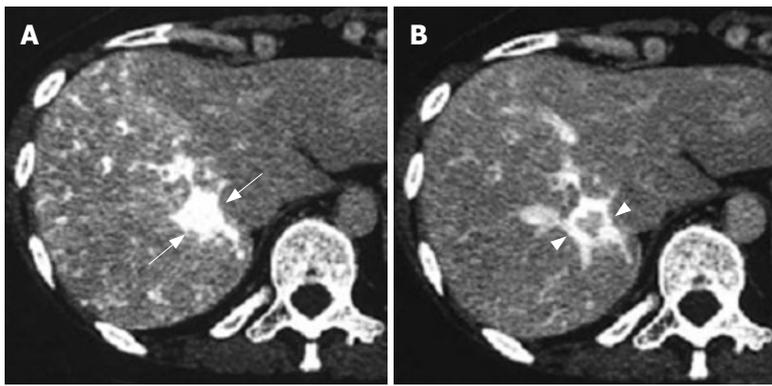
CT angiography showing the conspicuously enhanced lesion in segment 7 through the early phase (arrows) (A) and intensified tumor rim enhancement through the delayed phase along with radial enhancement (arrowheads) (B).
